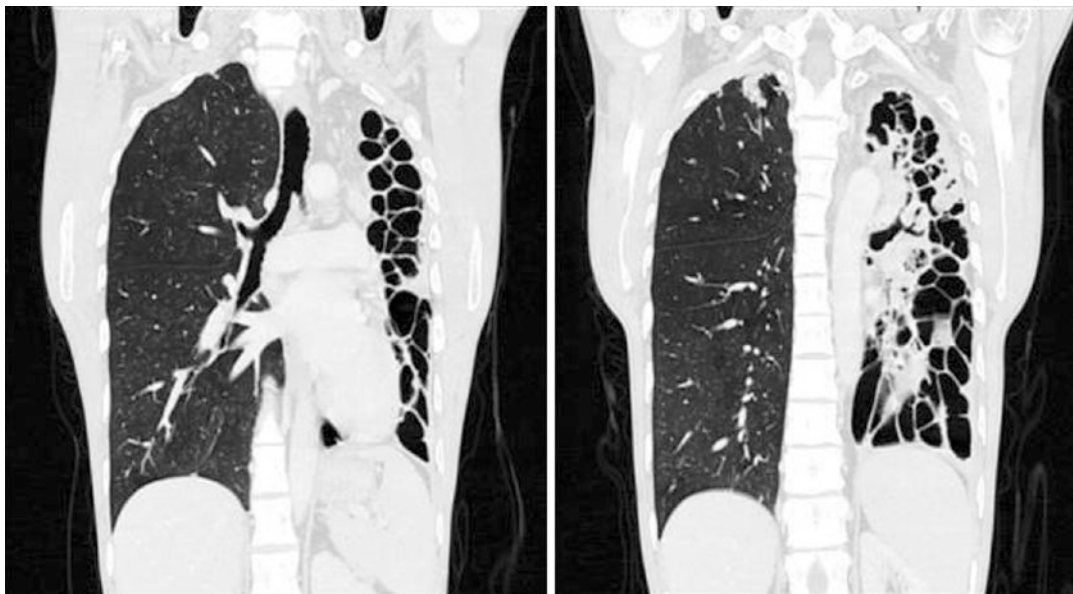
CT image showing left-sided post tubercular destroyed lung requiring pneumonectomy
